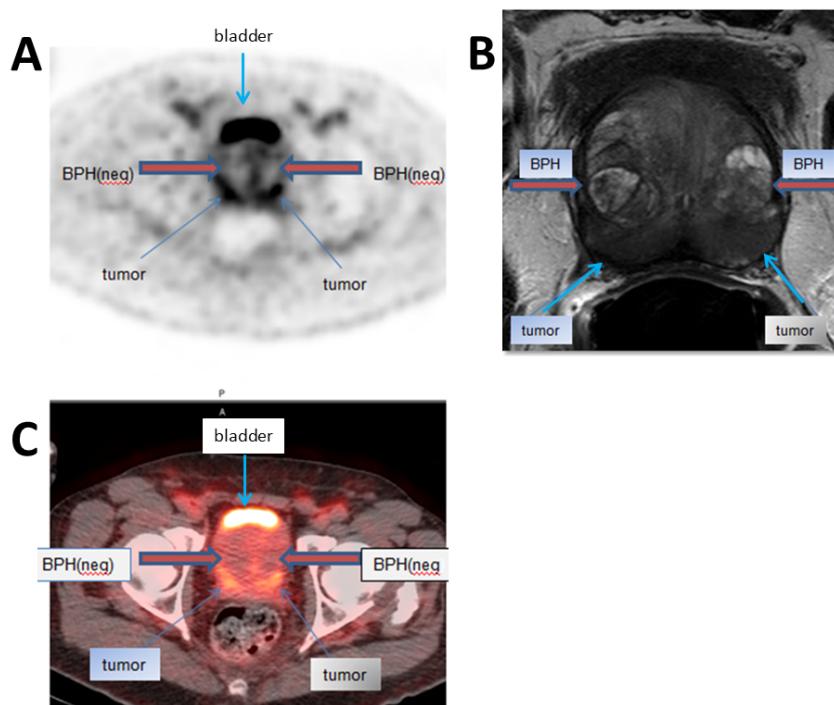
Localized prostate cancer images in patient with high risk cancer (A) Axial ^{18}F -DCFBC PET demonstrating focal uptake in tumor but not in benign prostatic hyperplasia. (B) Corresponding MR image showing malignant and benign lesions. (C) Axial ^{18}F -DCFBC PET and CT fusion image.
